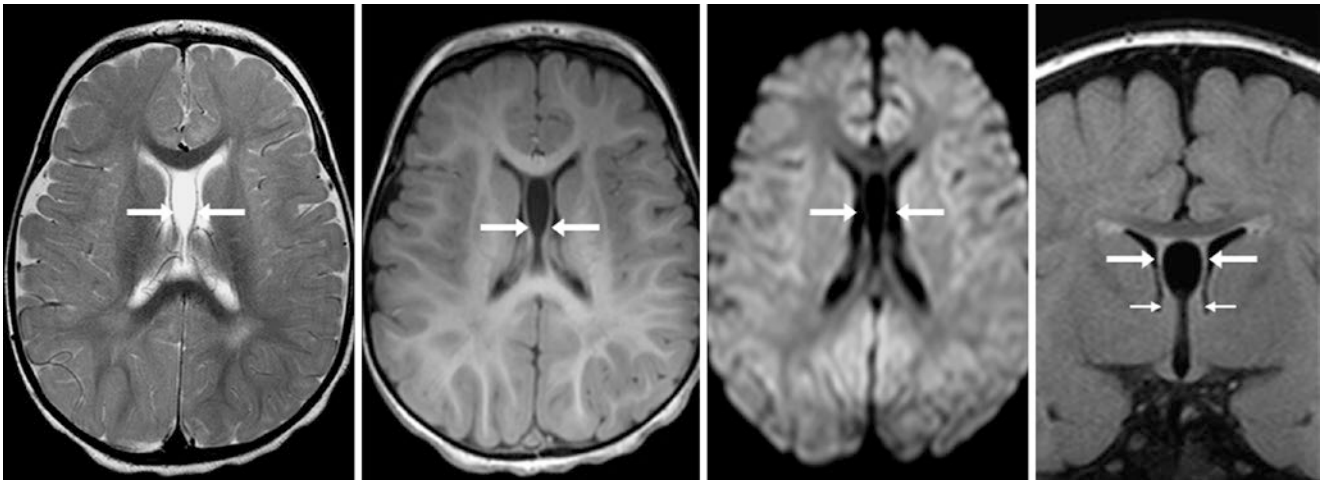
A 1 year old who underwent a 3T MRI that shows the extent of a CEV (*arrows*) on axial T2WI (*left*), T1WI (*left middle*), and DWI (*right middle*). Coronal FLAIR images (*right*) depict how the septae connect to the fornical columns (*tiny arrows*)
